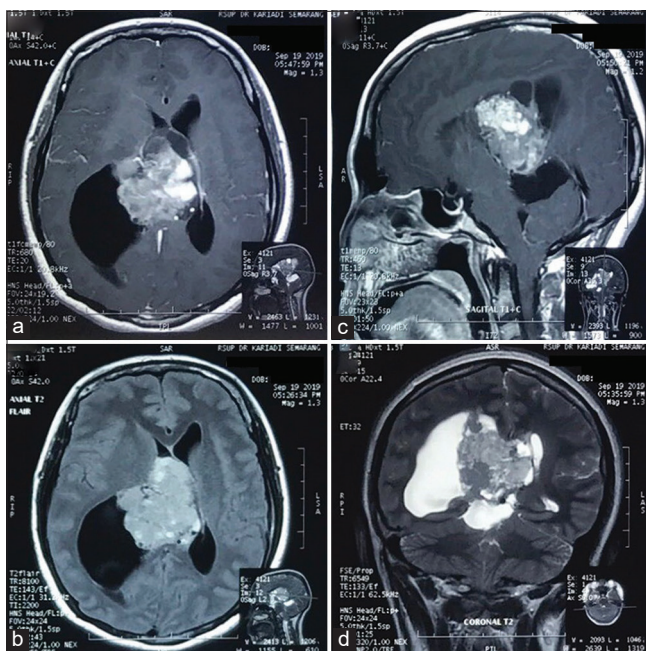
Pre-operative magnetic resonance imaging (A and C: T1+C; B: T2 Flair; D: T2) demonstrated an inhomogeneous intraventricular mass in the right lateral ventricle (AP 5.63 × CC 5.36 × LL 5.16 cm) attached to septum pellucidum with minimal intratumoral bleeding, cerebellar herniation, and signs of an increased intracranial pressure
